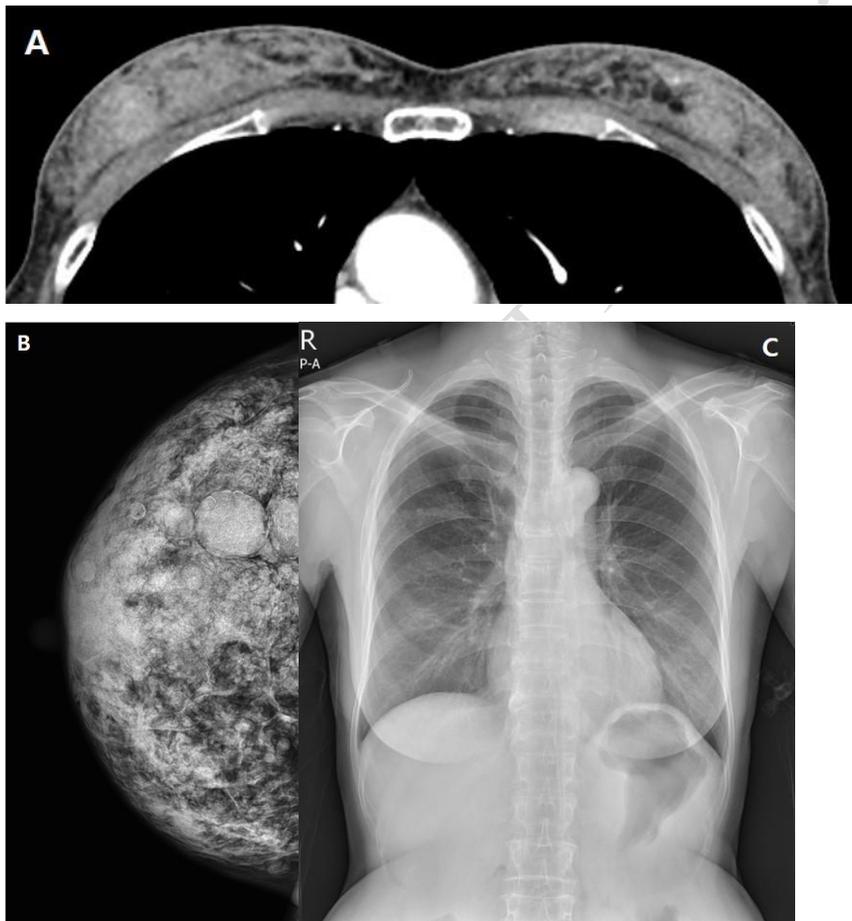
A: Chest CT demonstrating a mild increase in opacity in both breasts. Some areas show small round calcifications, whereas extensive calcification is rare, B: Mammography showing multiple granulomas corresponding to areas of increased opacity on CT, consistent with paraffin granuloma. The absence of ‘eggshell’ calcification helps distinguish it from silicone granuloma, C: Chest PA showing no obvious
